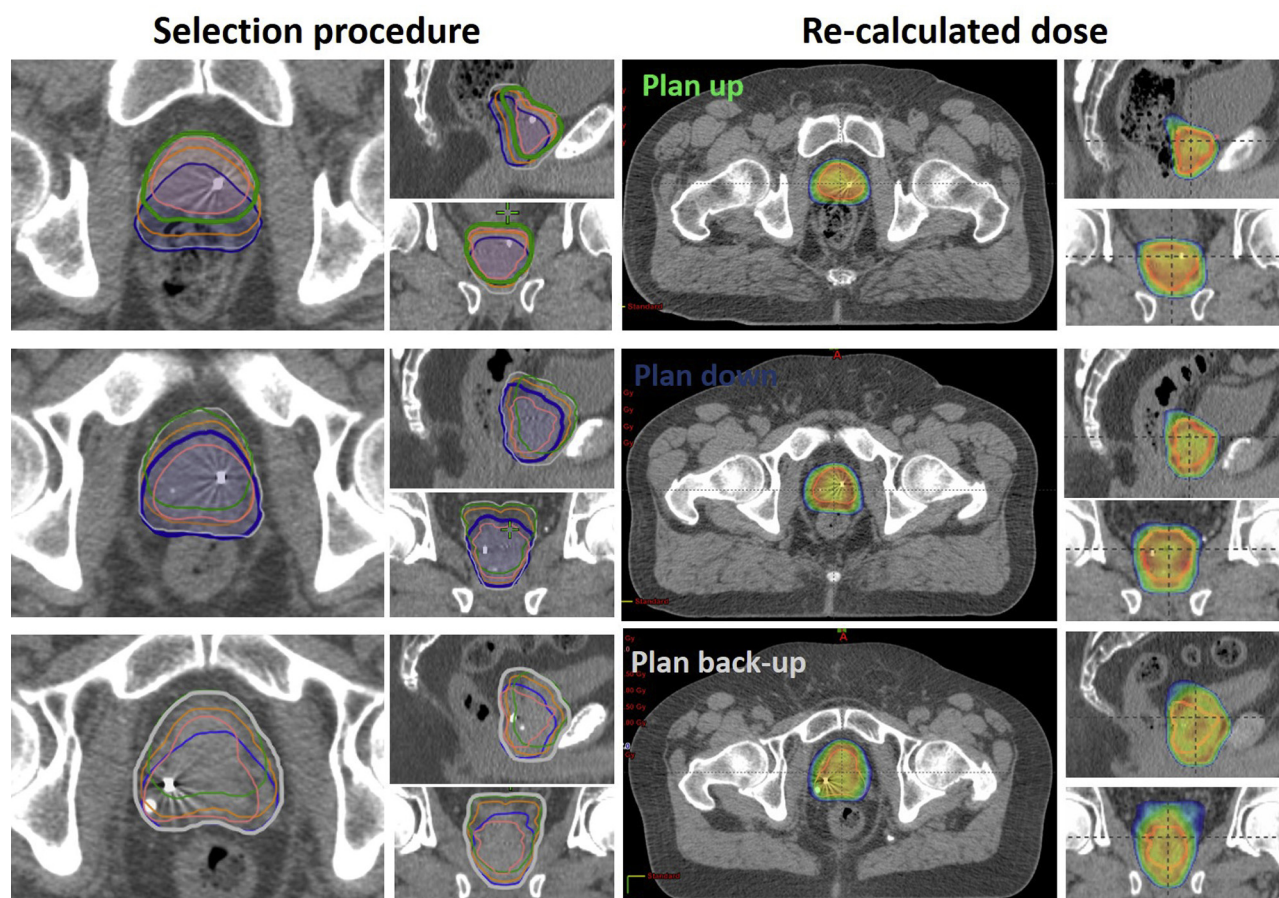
Examples of plan selection after the bony anatomy match of the repeat computed tomography to the plan computed tomography in patient 20 (top), 23 (middle), and 25 (bottom). Selected plans are visualized with bold contours (left column), with color coding the same as for Figure 1 and backup plan in gray. The dose distribution of the selected plans is shown with a 95%-dose threshold (right column). (A color version of this figure is available at <https://doi.org/10.1016/j.ijrobp.2019.11.007>).
